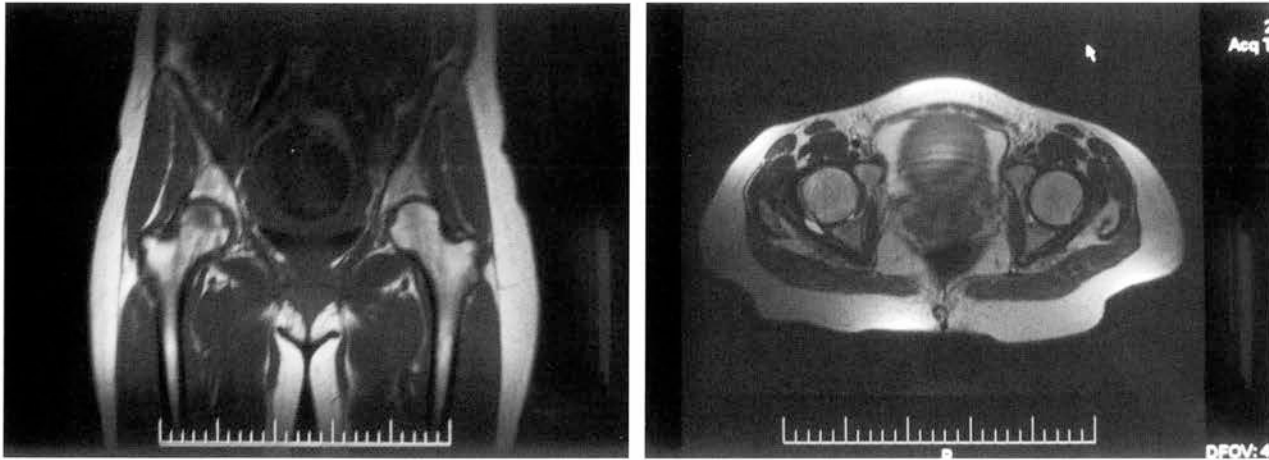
Magnetic resonance images of the hip demonstrating fluid accumulation. An oedematous aspect of the bone of the femoral head with no evidence of focal lesions is present on T1-weighted images low signal intensity (coronal section, left image) and on T2-weighted images high signal intensity (transverse section, right image).
